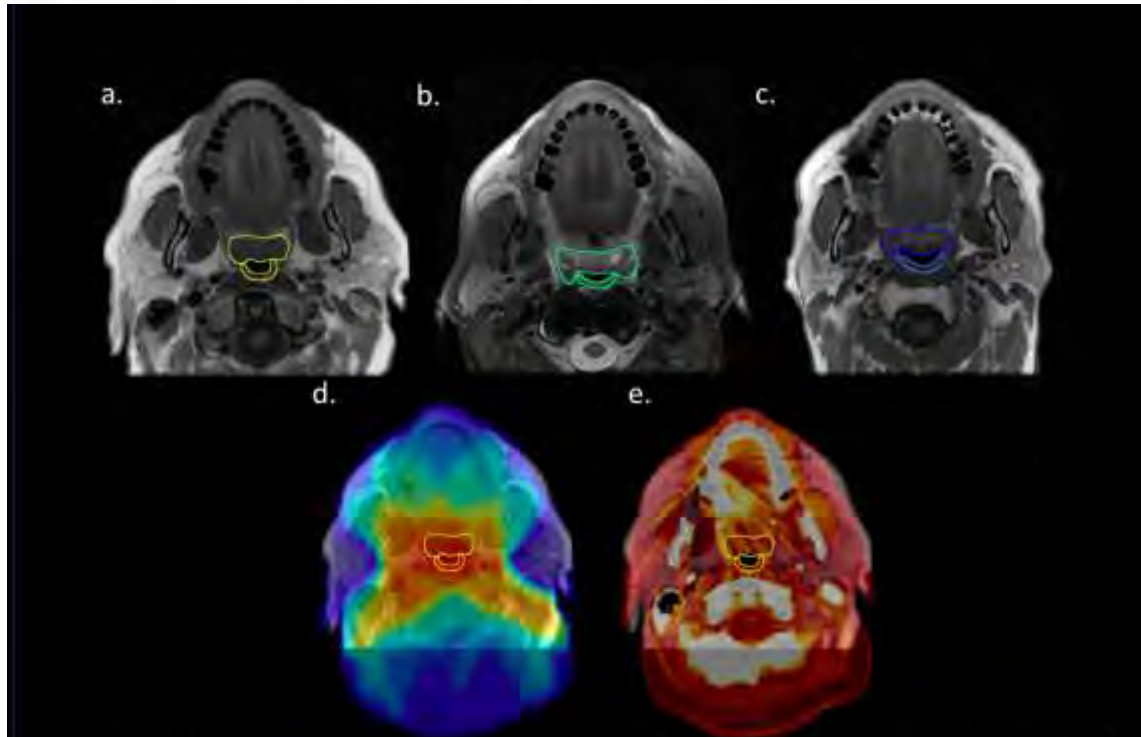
1a) T1 Baseline. 1b) T2 Early Post-RT after 3 months 1c) T1 Late Post-RT after 29 months 1d) Radiation dose grid 1e) Co-registration of MRI and planning CT
